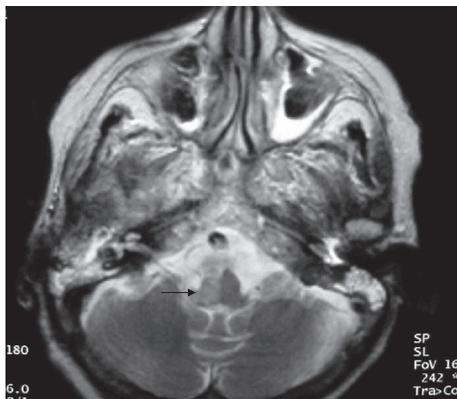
T2-weighted MRI, showing an infarct involving the right hemimedulla (arrow) (de Freitas et al., 2001).
